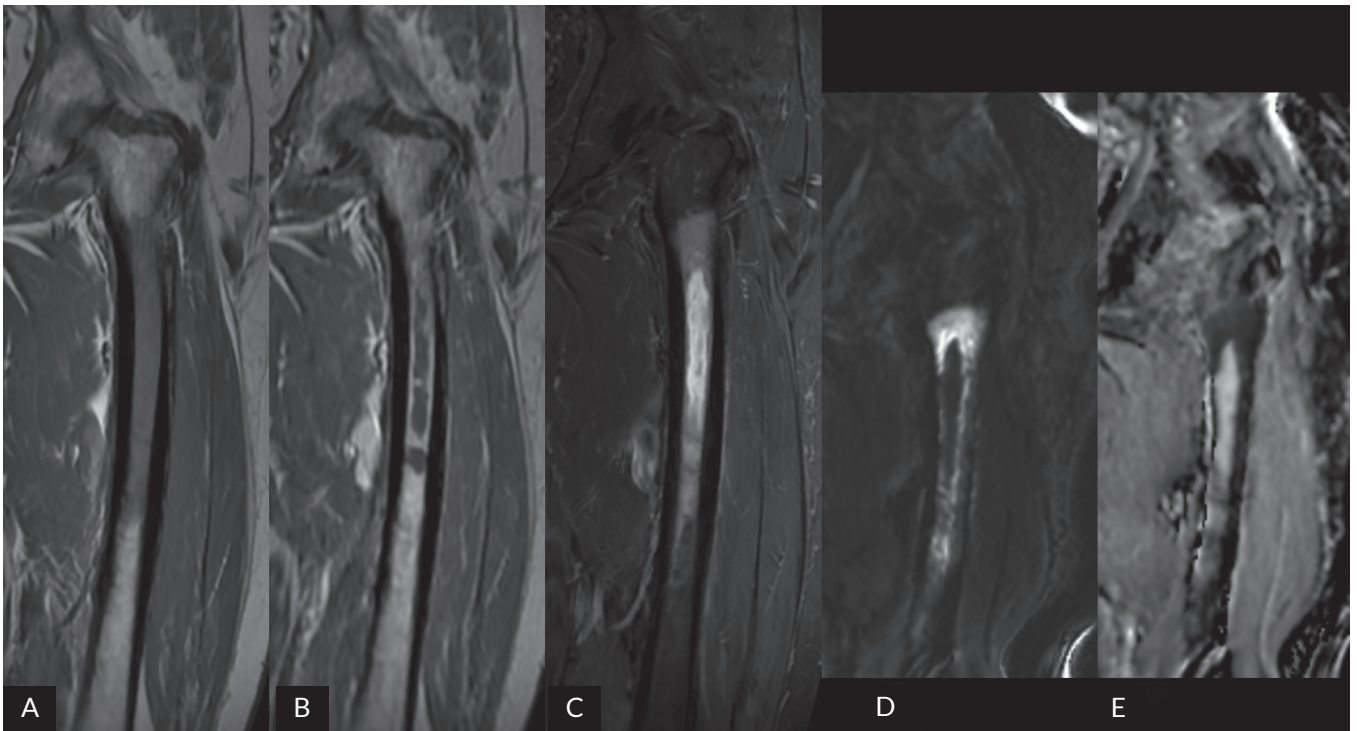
Selected coronal MRI scans of the left thigh show lymphoma involvement of the left femur. A. Pre-contrast T1-weighted image. B. Post-contrast T1-weighted image. C. STIR image. D. DWI image. E. ADC map
